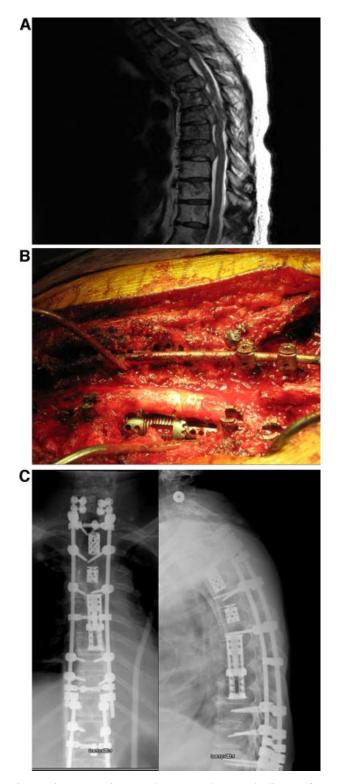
A: Preoperative MRI demonstrated metastatic disease of the spine with kyphosis and canal compromise. B: Multi-segmental lateral extracavitary corpectomy of levels T2, T4, and T6–T8 was performed. Expandable cage was placed in multisegment defect and expanded to appropriate height. C: Follow-up X-ray at 3 months demonstrated maintenance of correction. [Color figure can be viewed in the online issue, available at www.interscience.wiley.com.]
